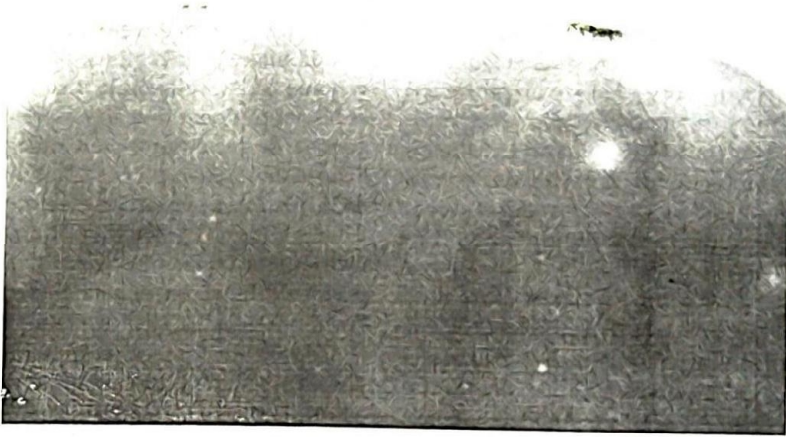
Periapical radiograph showing periradicular radiolucency involving right deciduous first and second mandibular teeth.
